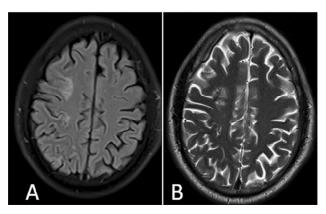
A 15-year-old female came to the hospital with complaints of generalised tonic-clonic seizure since five hours. The patient underwent MRI scan (A) Diffusion-weighted image showing diffuse restriction in subcortical regions of bilateral parietal lobes (watershed territory infracts). (B) Axial FLAIR and (C) axial T2 weighted images demonstrate high signal intensities in the corresponding areas suggestive of cytotoxic oedema.
